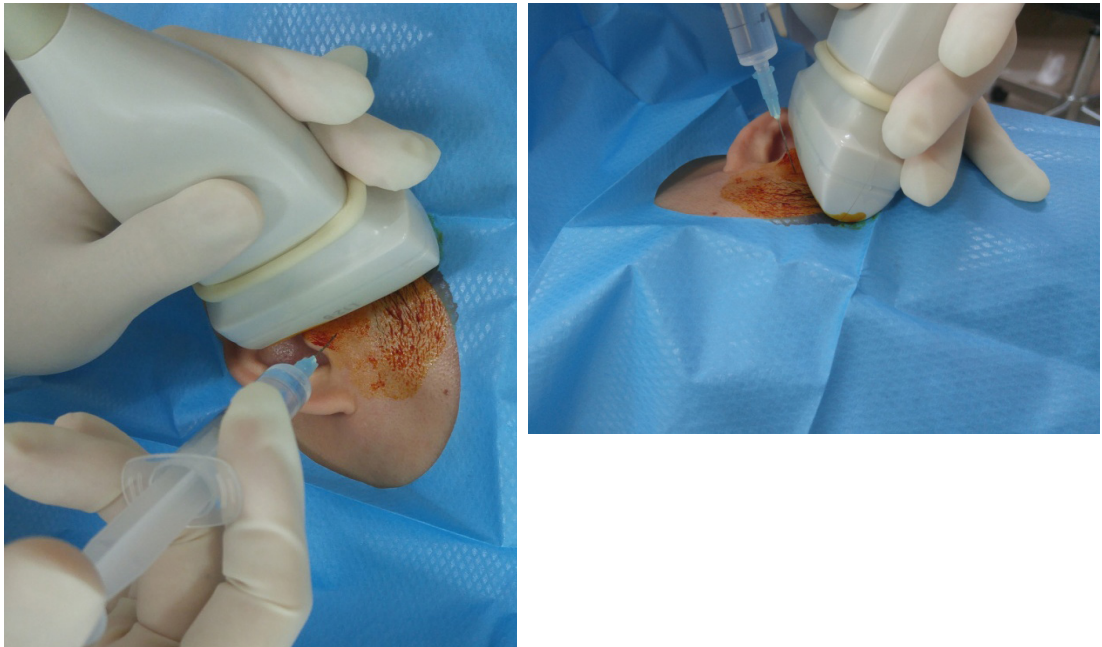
Position of ultrasound transducer and ATN block in out-of-plane.
